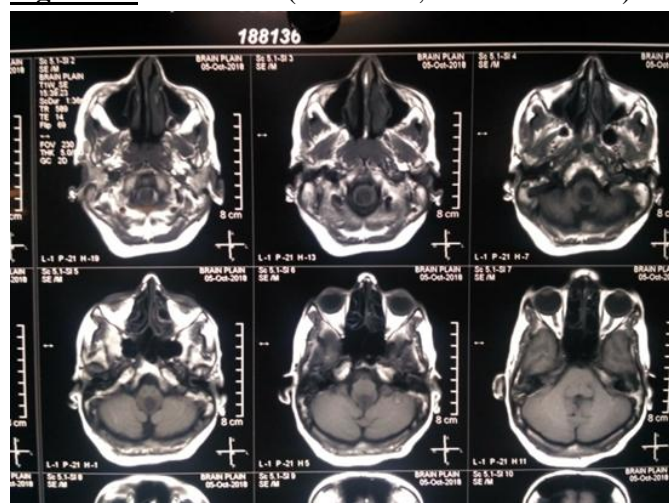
MRI Head (axial view, without contrast) at time of presentation was unremarkable.
